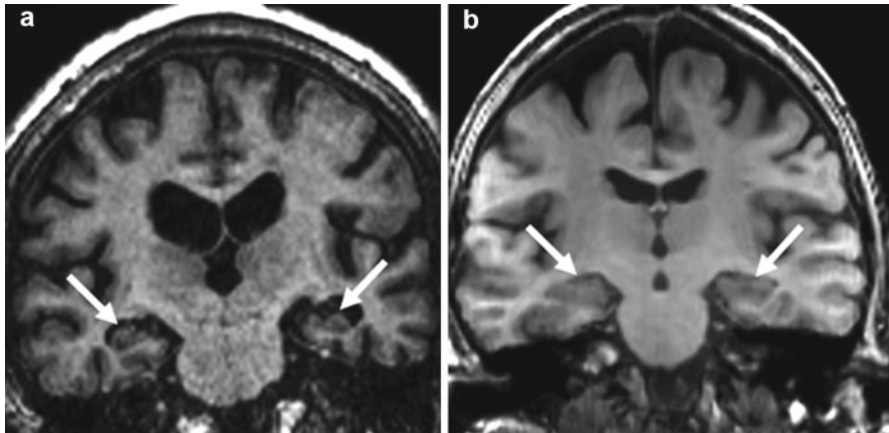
(a) Coronal T1-FSPGR MRI of an Alzheimer's patient shows atrophy of the hippocampi (*arrows*). (b) Normal hippocampi are included for comparison
